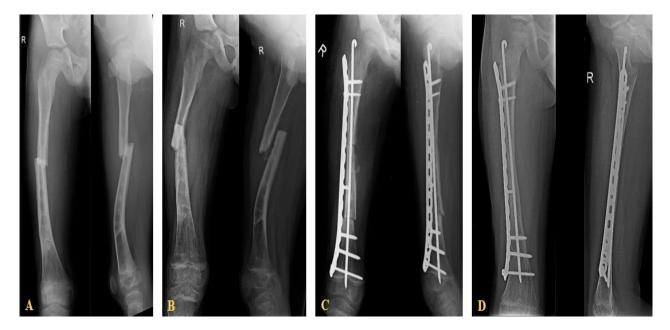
(A) Re-fracture of the right femur seen on the x-ray of right femur AP and lateral views 9 months post implant removal (B) X-ray after 8 weeks of hip spica showing unsatisfactory fracture healing (C) X-ray post open
